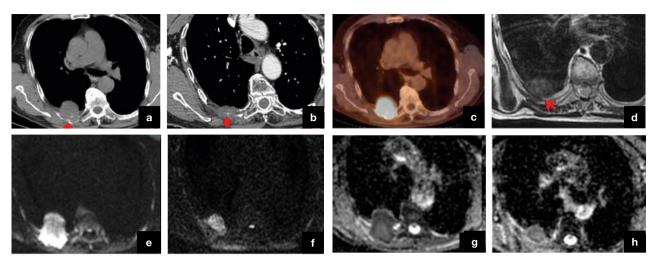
Seventy-two years old male patient with SCC. The mass appears to have invaded the chest wall. a: Prettreatment non-enhanced CT imaging b: Posttreatment enhanced CT imaging c: pretreatment PET-CT d: Posttreatment T2 WI e: Pretreatment DWI f: Posttreatment DWI g: Pretreatment ADC h: Posttreatment ADC.
